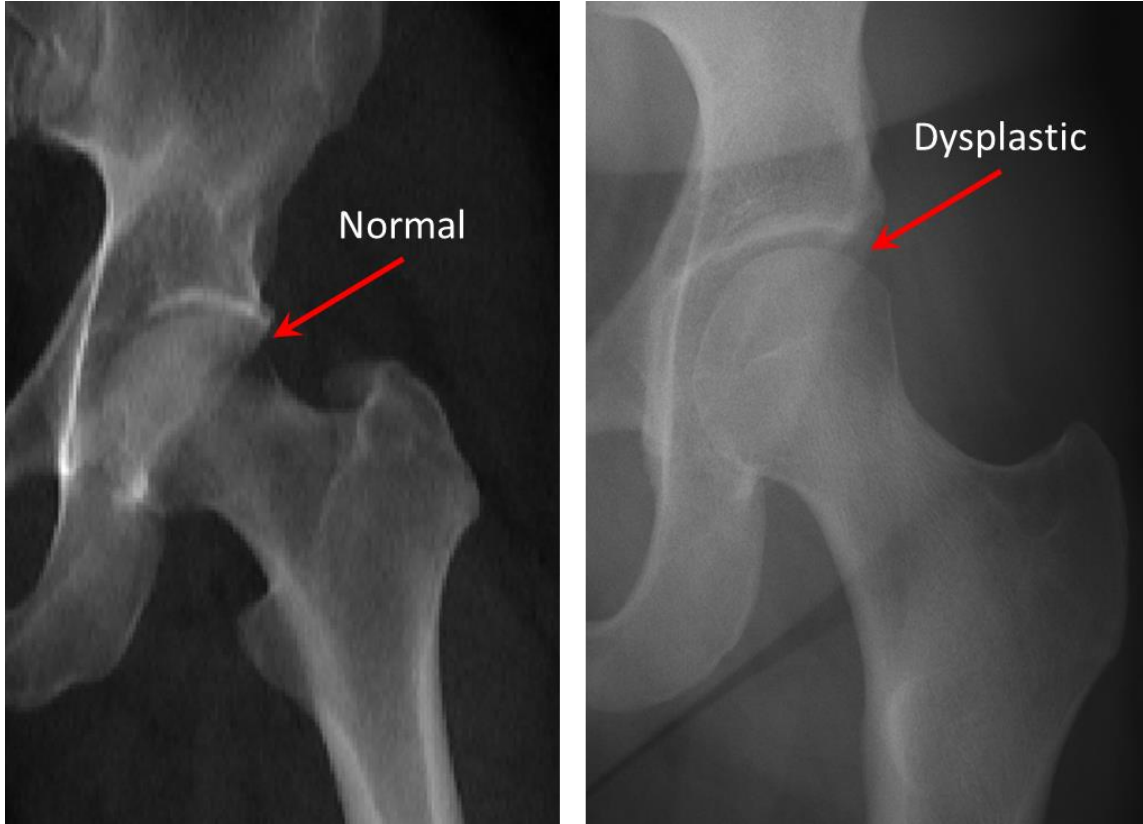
(Left) Orthographic projection of a normal hip joint generated from CT images. (Right) X-ray image of a dysplastic hip joint with a shallow acetabulum, inadequate coverage of the femoral head, and femoral head flattening.
